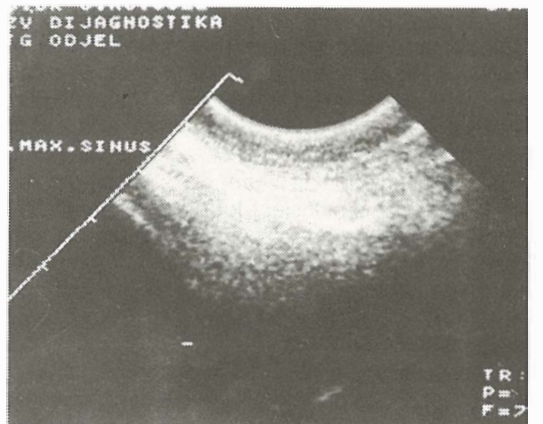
Ultrasound finding of the same patient after treatment. Finding clear.
